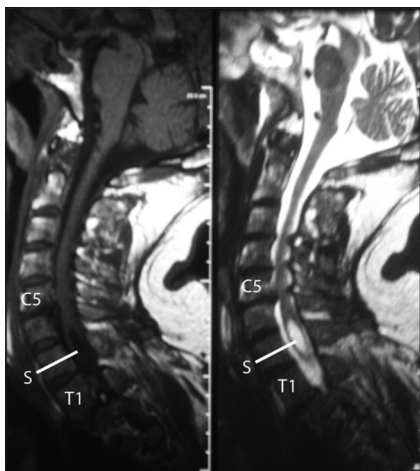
Preoperative magnetic resonance imaging of the cervical spine of the patient (left: sagittal unenhanced T1-weighted, right: sagittal T2-weighted) showing right centrolateral C5–C6 disc herniation, cervical spondylosis from C3–C4 to C6–C6, and a syringomyelia cavity (marked “S”) extending from C6–C7 to T1 levels.
